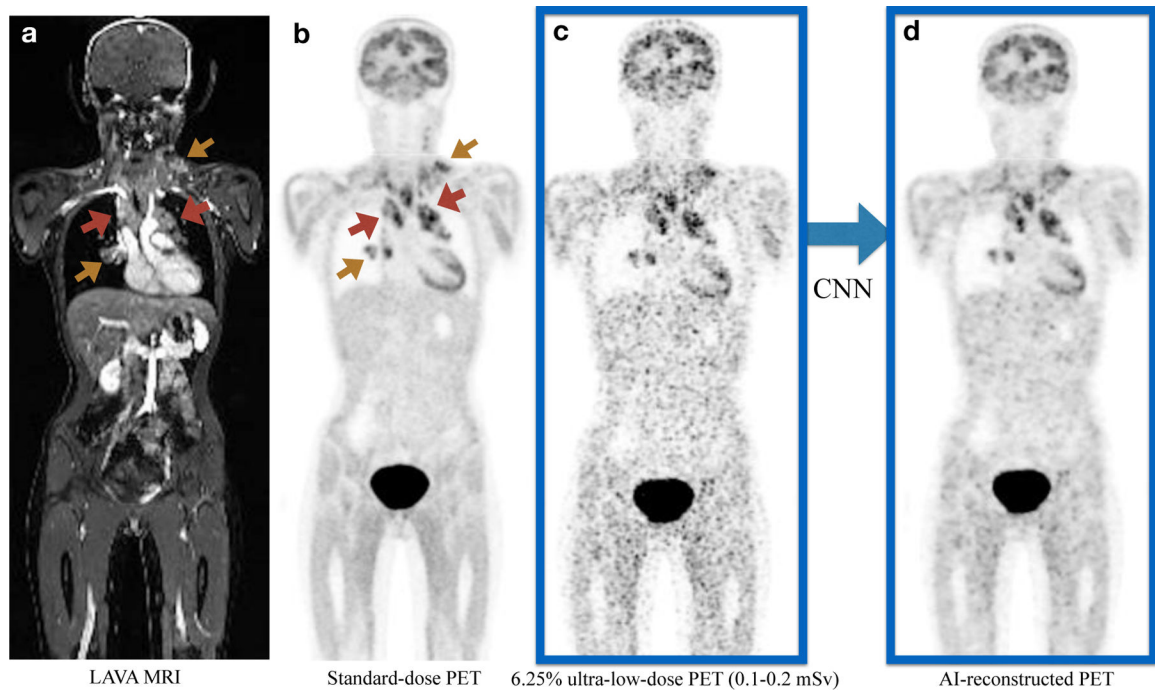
Representative ^{18}F -FDG PET/MRI scan of a 16-year old female patient with Hodgkin lymphoma (HL).
